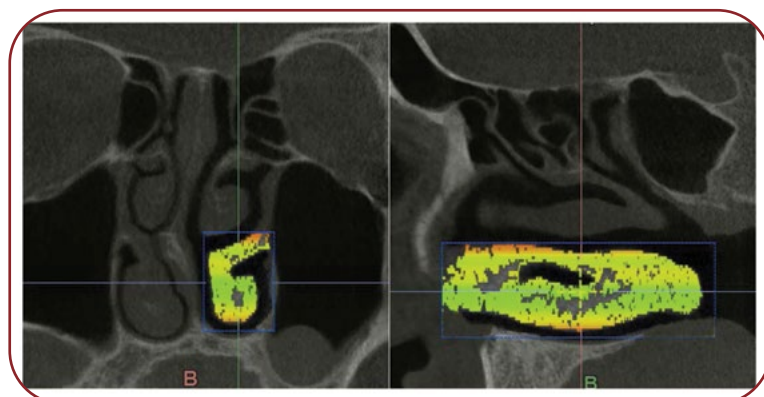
Screenshots of the cone-beam computed tomography view showing the assessment of the volume of the inferior turbinate. The color continuum reflects the volume of the identified soft tissue at each transverse plane, with green showing the largest volumes of soft tissue and orange showing the smallest volumes. The coloring is done by the measuring software, and not by the authors.
